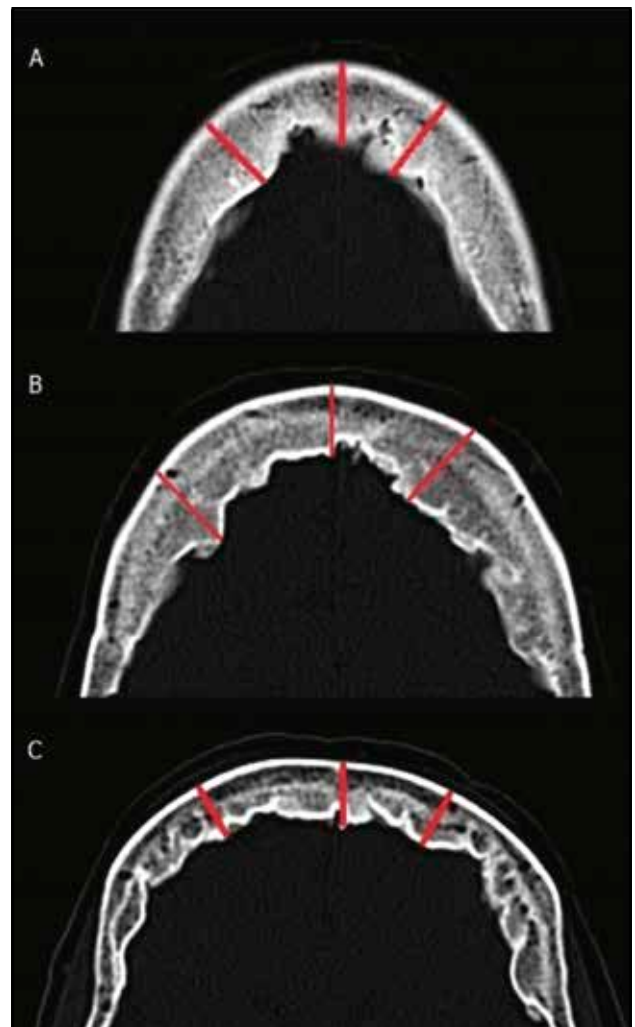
Cranial CT scan, axial plane. Cranial bone thickness measurements were performed at 3 levels of the frontal bone. A: Vertex level, B: Frontal tuberosity level, C: Frontal sinus level.
